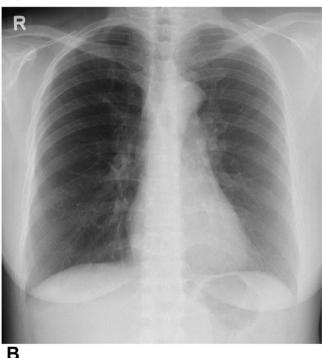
(A) Chest radiograph at time of initial presentation. (B) Chest radiograph 6 months later.
